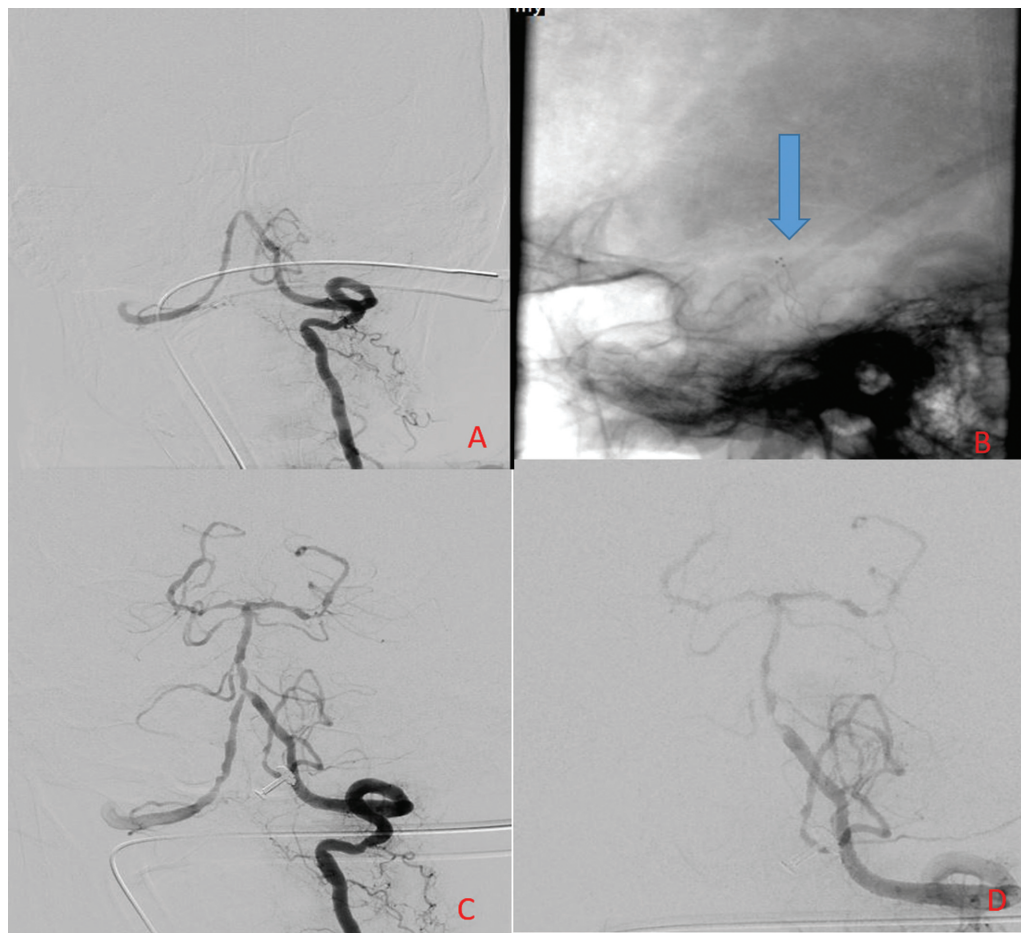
An elderly patient with a known history of smoking and long-standing hypertension presented with symptoms of posterior circulation stroke that had been ongoing for 20 hours. Computed tomography (CT) angiography revealed proximal occlusion of the basilar artery with multiple calcified plaques. (A) Left vertebral artery digital subtraction angiography (DSA) run in anterior-posterior (AP) view shows nonvisualization of the basilar artery. (B) A stent retriever (arrow) was deployed across the occlusion in the basilar artery. (C) Check run after the first pass shows complete recanalization of the basilar artery with visualization of bilateral posterior cerebral artery (PCA). There are multifocal areas of long-segment focal narrowing and lumen irregularity in the basilar artery suggestive of intracranial atherosclerotic disease (ICAD) changes. (D) Check the DSA run after 10 minutes showing reocclusion appearing in the proximal basilar artery. After that, it was completely occluded again.
